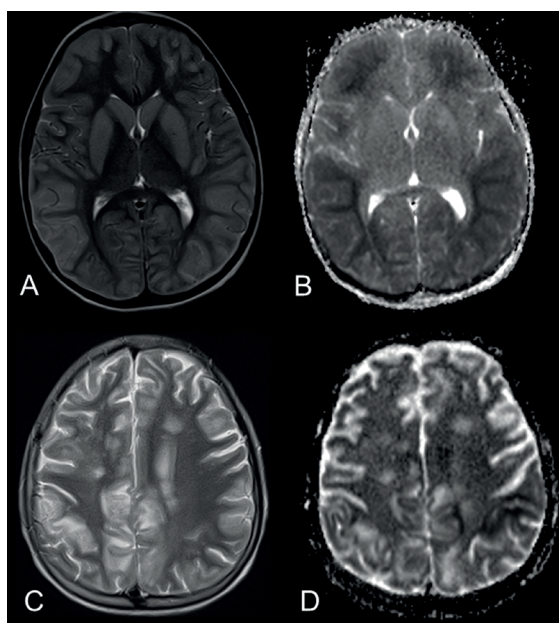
MRI of a 5-year-old male patient after weaning showing diffuse cortical hyperintensity on T2-weighted MR image (A) and restricted diffusion with prominent signal loss in cortex on ADC map of diffusion weighted image (B) consistent with hypoxic ischemic encephalopathy. (C) Axial T2W MR image of a 13-year-old female after weaning demonstrating patchy hyperintense lesions in cortex and (D) subcortical white matter in both frontal and parietal lobes with heterogeneous signal on ADC maps of diffusion weighted image, consistent with PRES.
